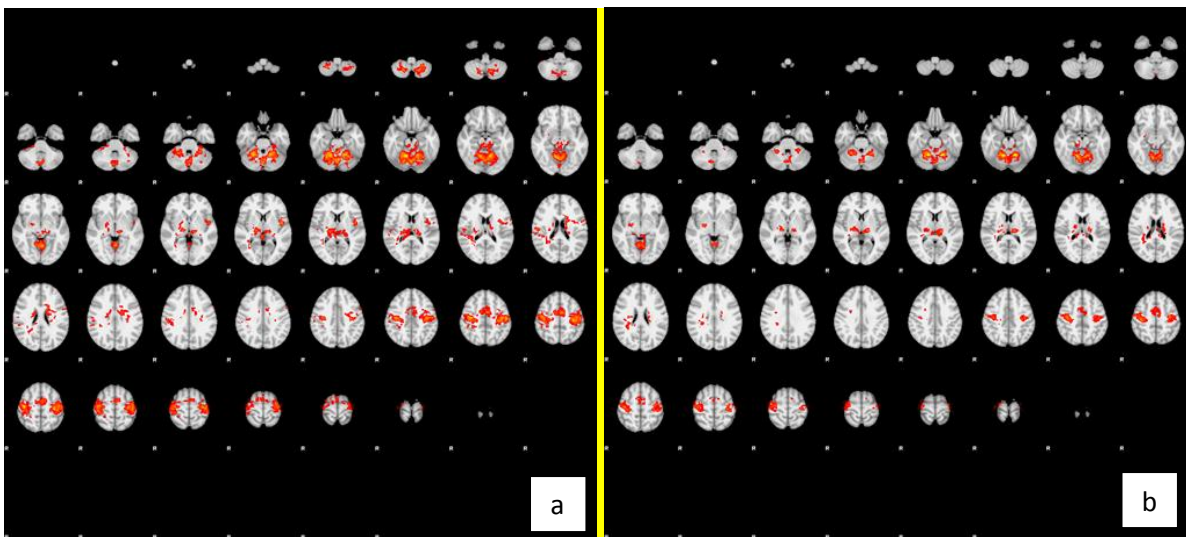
Pre alprazolam (a) vs. post alprazolam (b). The orange red marks on a MRI T1 anatomic multiple slices axial template, correspond to areas activated by motor task.
